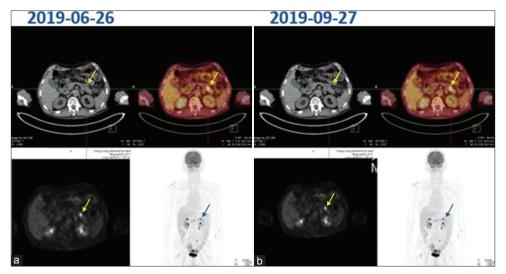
During the positron emission tomography—computed tomography (PET-CT) follow-up on September 27, 2019, a pancreatic lesion was detected (b, arrow). Retrospective analysis of the PET-CT from June 26, 2019, revealed the presence of the lesion, but it had undergone minimal change (a, arrow)
